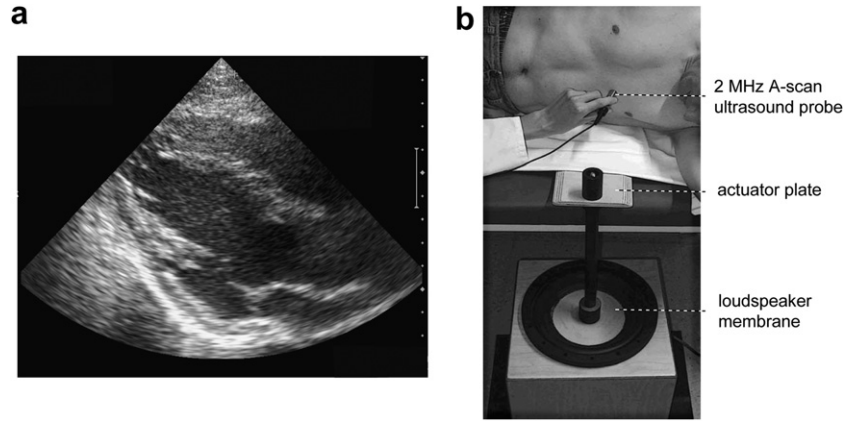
Experimental set-up of time-harmonic cardiac elastography. (a) B-mode of the heart's long axis from a parasternal view as used for image guidance in A-line elastography. The target region for vibration measurements was in the inferior wall. (b) Continuous harmonic vibrations were induced from the lateral side of the chest by an actuator plate mounted to a loudspeaker.
